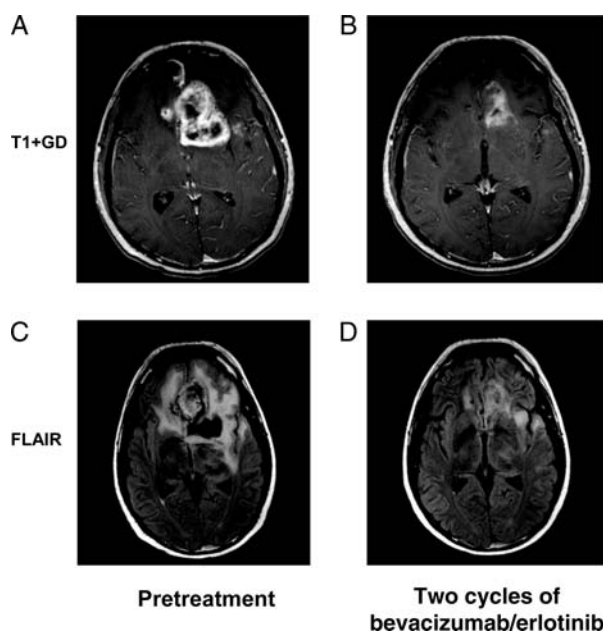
Representative radiographic response associated with bevacizumab and erlotinib in recurrent GBM.
